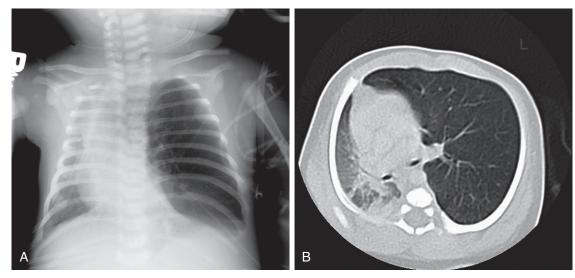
Congenital lobar emphysema. A, Anteroposterior chest radiograph. Left upper lobe shows hyperlucency of the affected globe, atelectasis of the lower lobe, and mediastinal shift. B, CT of same patient shows left upper lobe herniating across the midline with compression of structures on the right. (*Courtesy Beverly Newman, MD, Pittsburgh, Pa.*)
